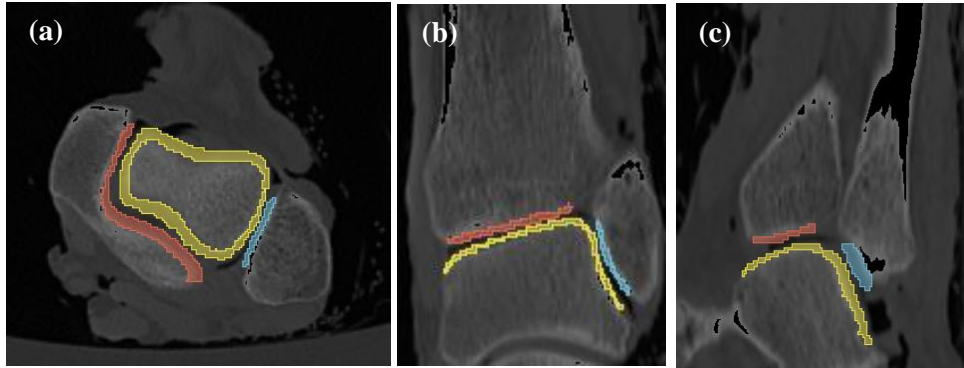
The CT scan images in three views show cartilages (yellow for talus; red for tibia; blue for fibula) at ankle joint. (a) the axial view; (b) coronal view; (c) sagittal view.
